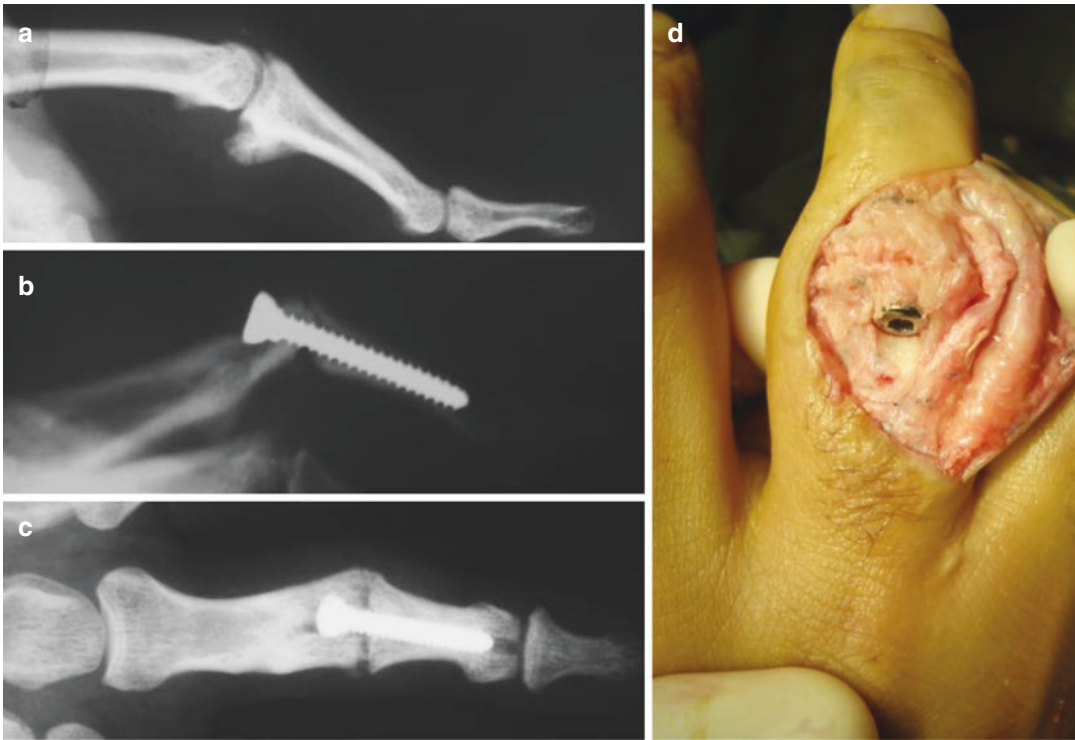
Clinical example for PIP fusion. (a) Preop X-ray. (b, c) Post-op X-ray using the compression intramedullary lag screw technique. (d) Intra-op aspect of the fixation during the surgery
